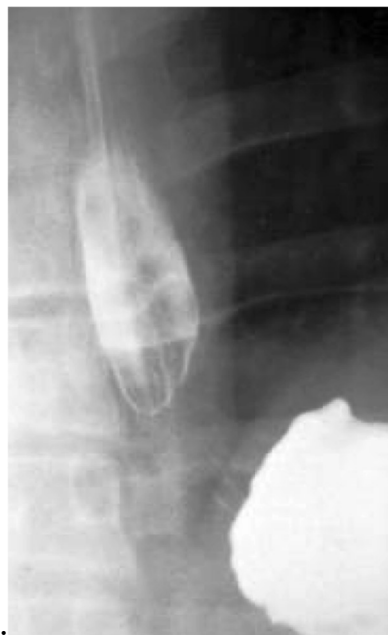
X-ray picture of the GEJ. During the abdominal compression there is a contraction of the LES, which caused the barium bolus to stop moving. The length of the gap between the barium-containing esophagus and the stomach is a LES contraction.
